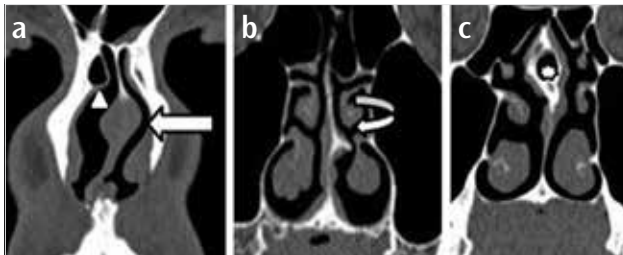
a-c. Coronal CT images of different patients showing: leftward deviation of nasal septum (arrow) and Agger nasi cell (arrowhead) extending to the right frontal recess (a), bony spur of nasal septum (curved arrow) extending to the left inferior concha and narrowing the nasal passage (b), pneumatization of posterior portion of nasal septum (asterisk) (c)
